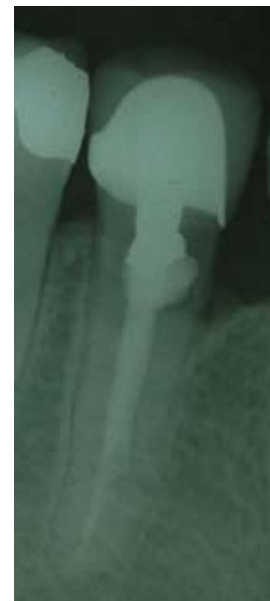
Preoperative radiograph of the lower right second premolar with invasive cervical resorption and root perforation.
